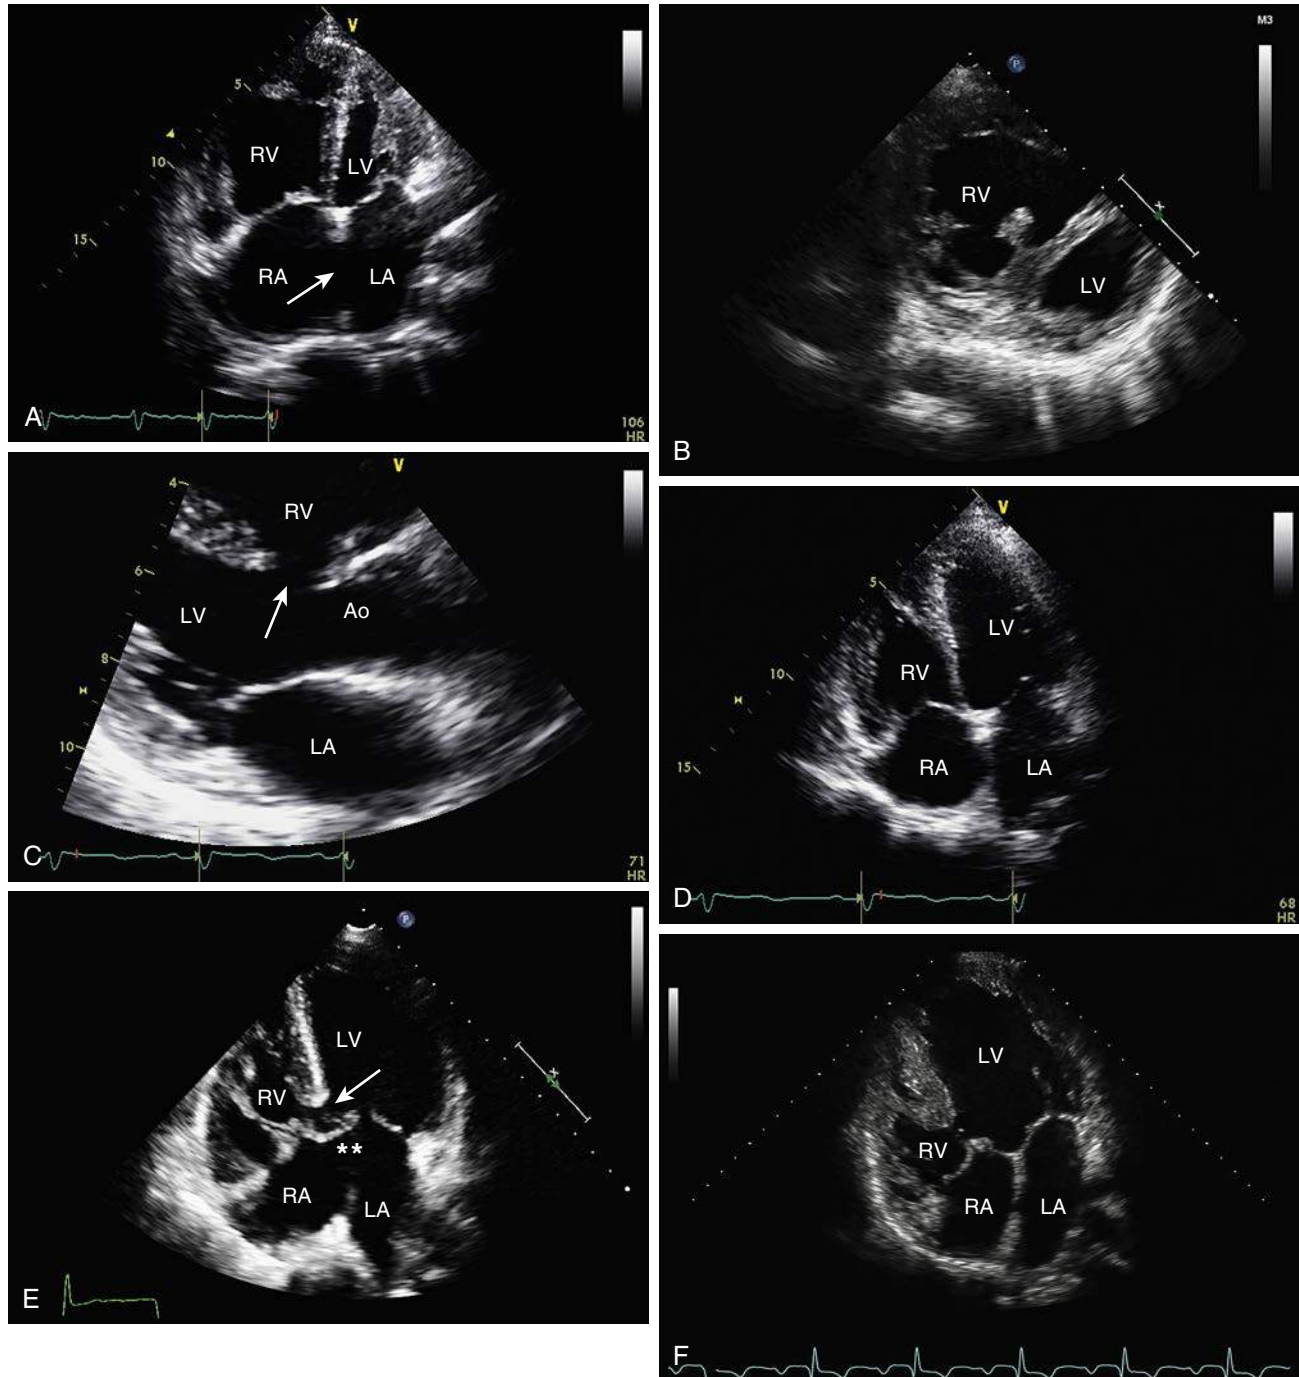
A and B, Large atrial septal defect (ASD) with Eisenmenger physiology in a 55-year-old woman. Note, remodeling of the right ventricle (RV) is different from that of the patient with a large ventricular septal defect (VSD). A, Apical 4-chamber view (end-diastolic still frame) with a large secundum ASD (arrow) and eccentric hypertrophy of the RV with severe dilation. B, Two-dimensional (2D) parasternal short-axis view (late systolic still frame) with severe eccentric hypertrophy of the RV and flattening of the interventricular septum. C and D, Nonrestrictive perimembranous VSD in a 43-year-old man with Eisenmenger syndrome. C, Two-dimensional (2D) parasternal long-axis view (early systolic still frame) shows a nonrestrictive perimembranous VSD extending to the outlet septum (arrow). D, Apical 4-chamber view (early systolic still frame). Note concentric hypertrophy of the RV. E, Complete atrioventricular septal defect in a 28-year-old woman with Eisenmenger syndrome. Apical 4-chamber view (end-diastolic still frame) with a large primum ASD (asterisk), an inlet VSD (arrow), and a common atrioventricular valve. Note concentric hypertrophy of the RV. F, Double inlet left ventricle (DILV), large inlet VSD and transposed great arteries, without pulmonary outflow tract obstruction, and Eisenmenger physiology in a 24-year-old man. The right-sided atrioventricular valve overrides the interventricular septum more than 50%, and the RV is hypoplastic. Ao, Aortic root; LA, left atrium; LV, left ventricle; RA, right atrium.
